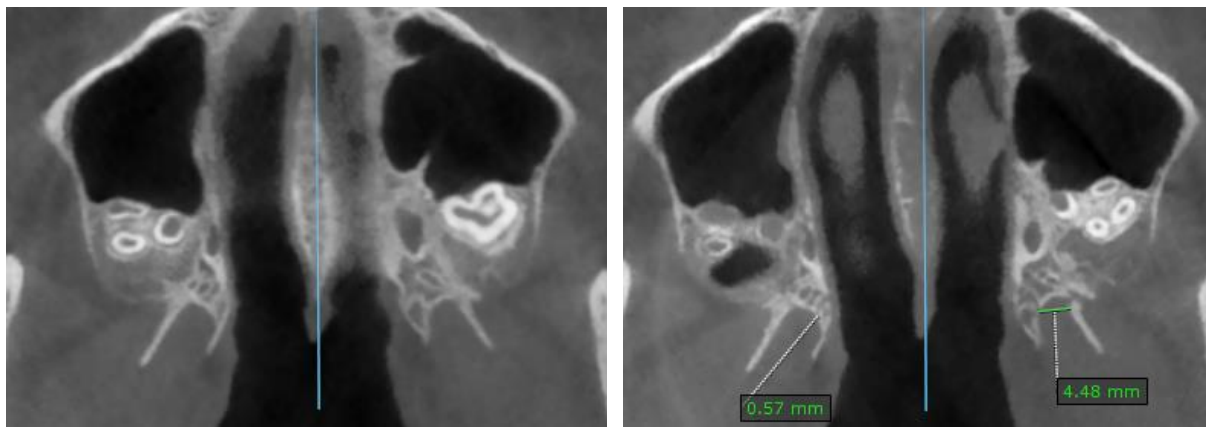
CBCT of a Hyrax patient. A: pre-expansion. B: post-expansion. Openings between the lateral and medial pterygoid plates detected on an axial slice situated between the axial palatal section (APS) and the lower nasal section (LNS) in the post-expansion CBCT.
